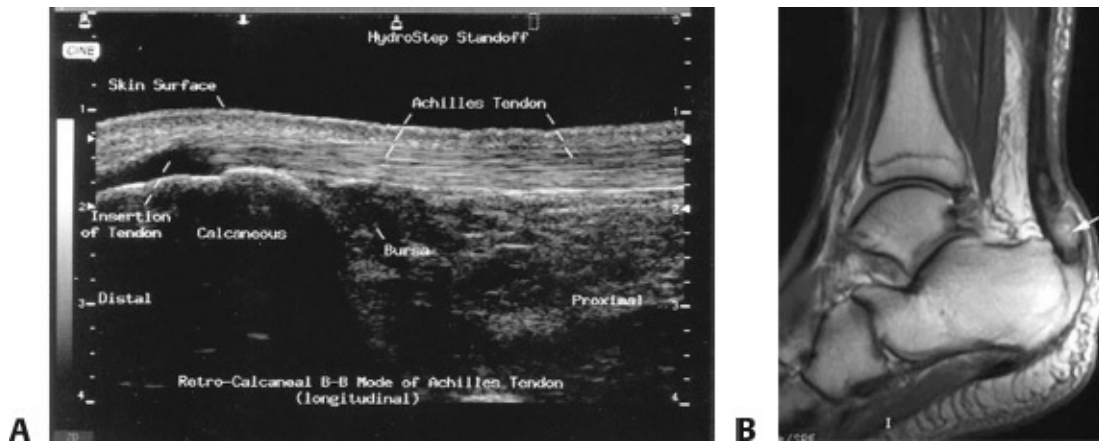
• A. Normal Achilles ultrasound image. B. Ankle MRI (T1-weighted image) showing a distal Achilles tendon rupture. (From Labib S. Open Achilles tendon repair. In: Wiesel S, ed. *Operative Techniques in Orthopaedic Surgery*. 2nd ed. Vol. 4. Philadelphia, PA: Wolters Kluwer Health; 2015:4967-4973.)
